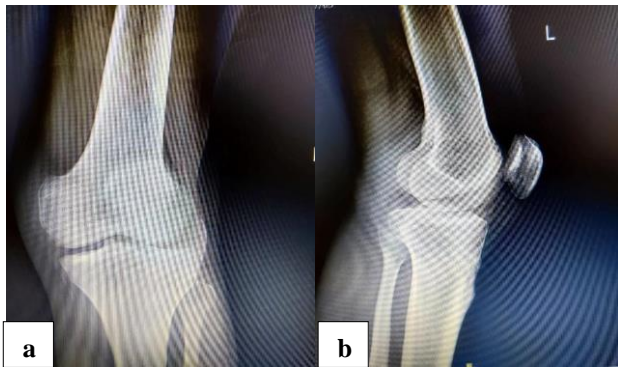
(a and b): Radiograph of left knee anteroposterior and lateral view.
